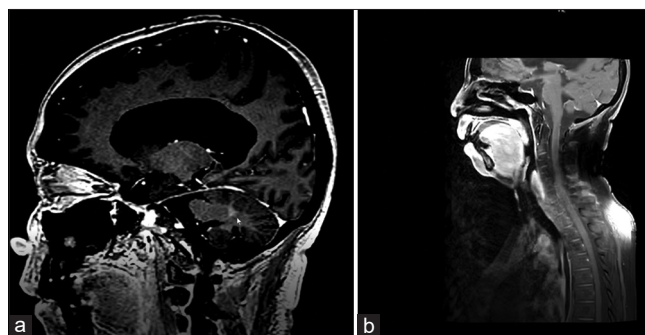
(a) CE-MRI brain (T1 post-contrast sagittal section image) showing subtle leptomeningeal nodular enhancement predominantly involving infratentorial compartment around the brainstem and along the cerebellar vermis; (b) MRI screening whole spine (T1 post-contrast sagittal section image) showing nodular leptomeningeal enhancement covering the entire spinal cord resembling ‘Sugar coating’ appearance
